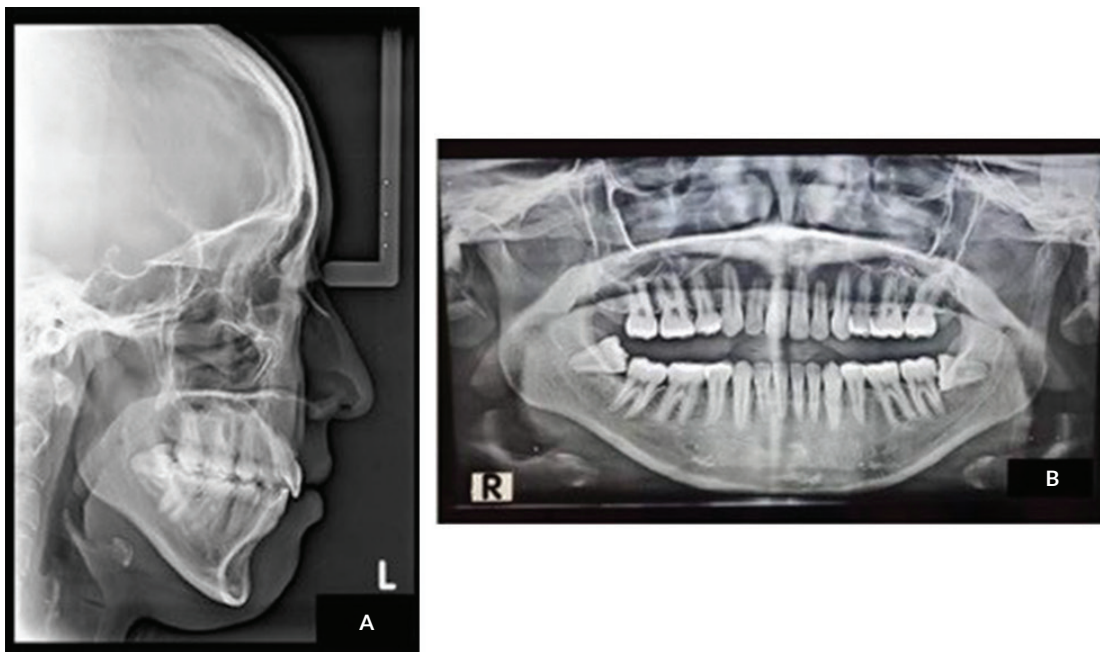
Post-treatment (A) lateral cephalometric and (B) panoramic radiographs.
